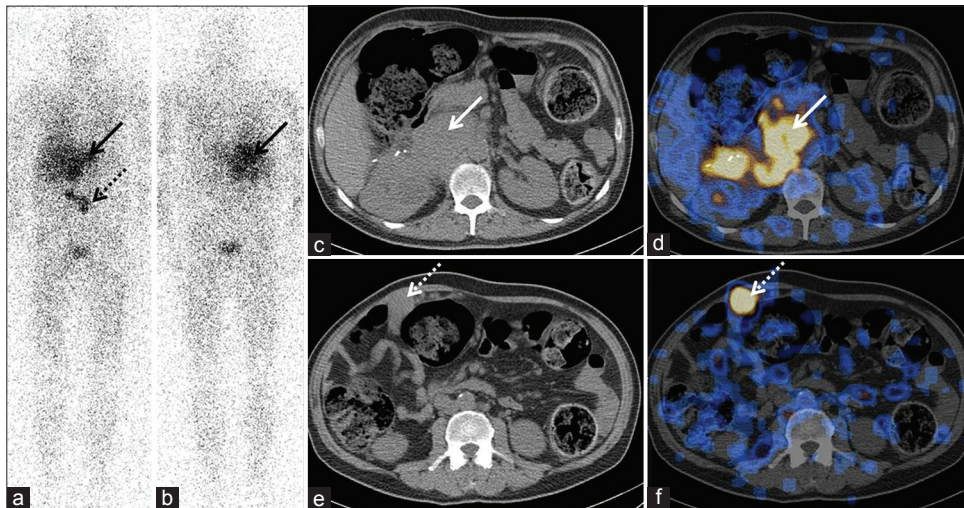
¹³¹I-MIBG planer whole body scintigraphy anterior (a) and posterior (b) images showing increased tracer uptake in upper and mid abdomen regions. SPECT/CT study revealed MIBG concentrating lesions involving aortocaval lymph node (c and d, arrows) and a omental deposit suggestive of recurrent disease (e and f, dotted arrows). ¹³¹I-MIBG = ¹³¹I-metaiodobenzylguanidine, SPECT = Single-photon emission computed tomography, CT = Computed tomography
